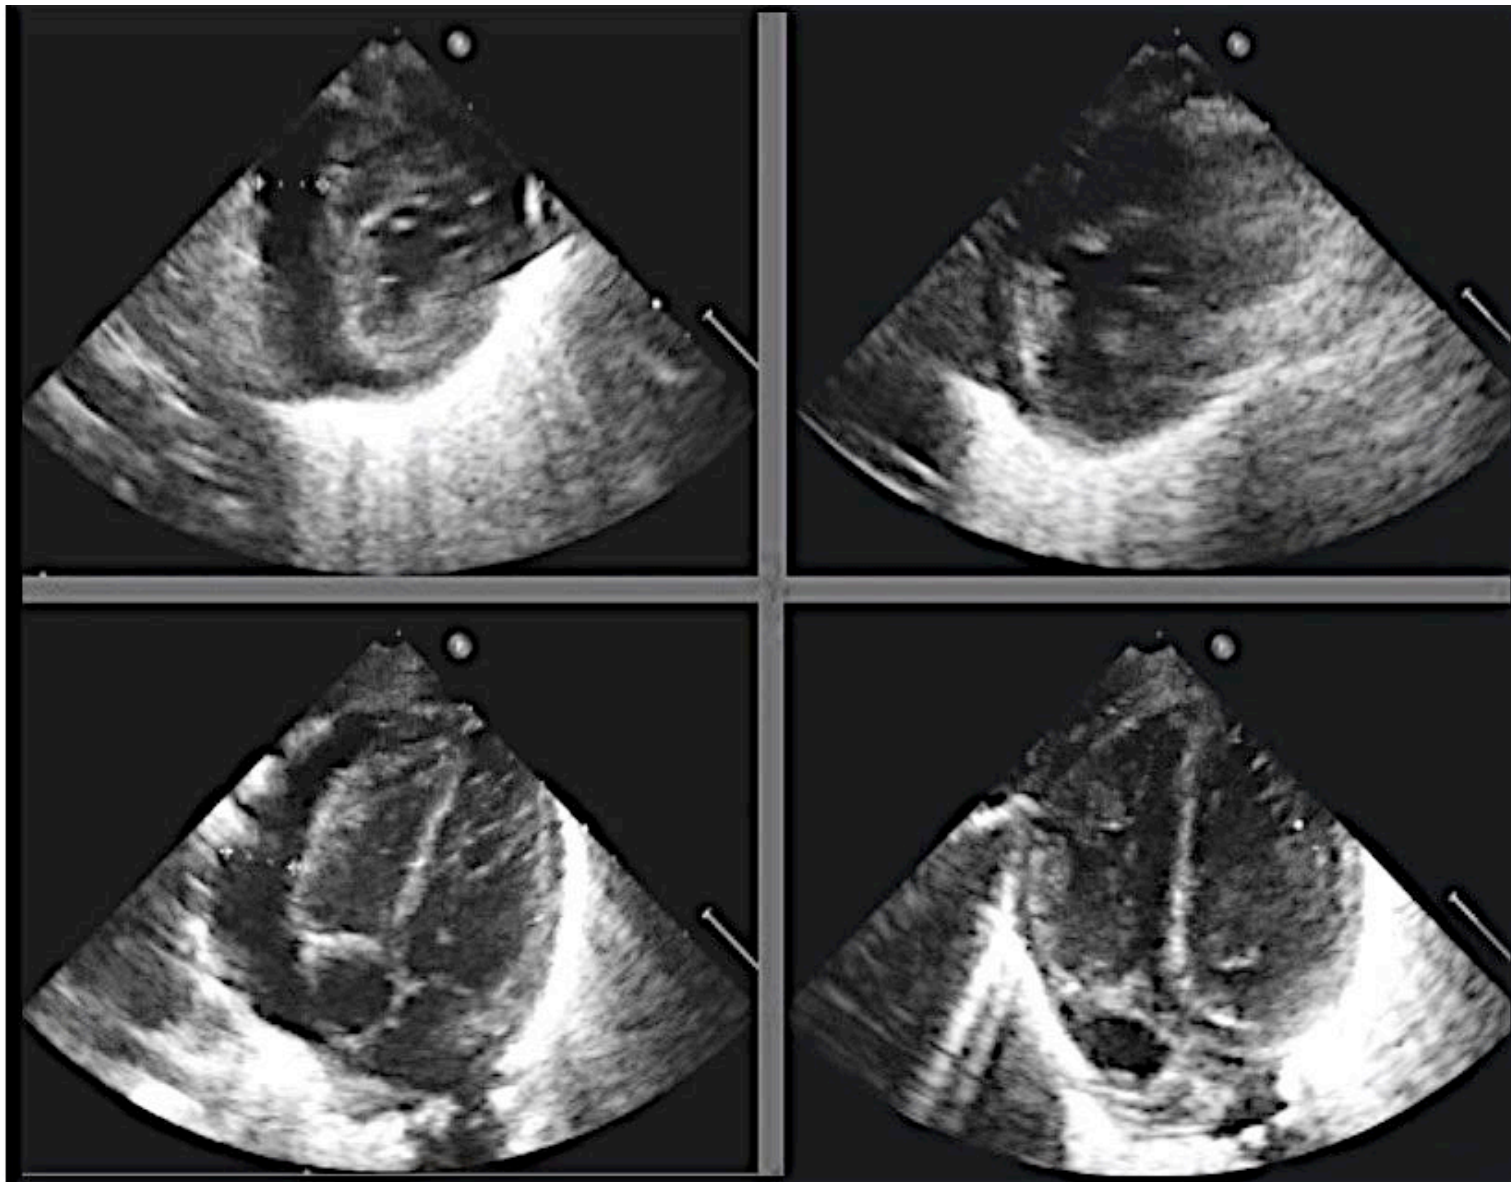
Echocardiograms (apical 4-chamber and short axis view) before and after UVC removal.
